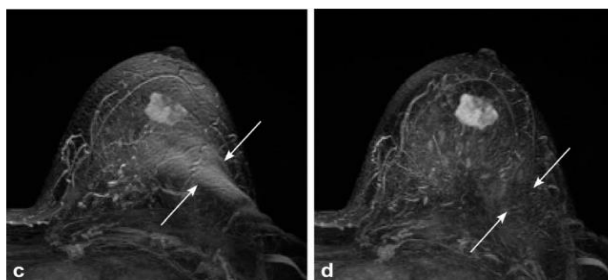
Sample view of a tumor MRI slice
